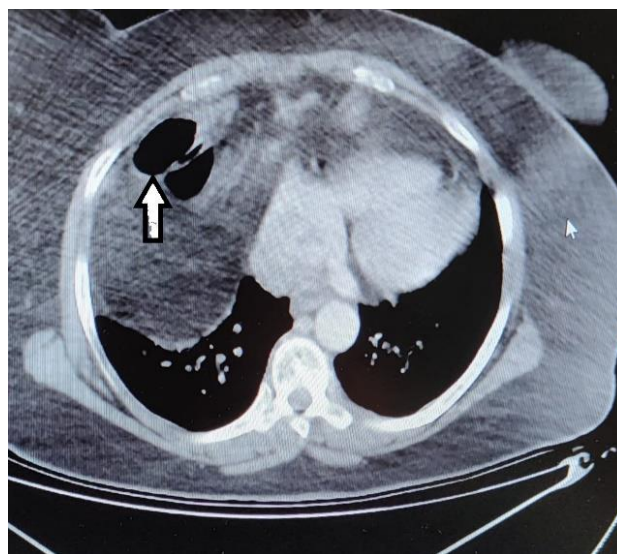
Toracoabdominal CT; Strangulated omentum and segment of transvers colon
